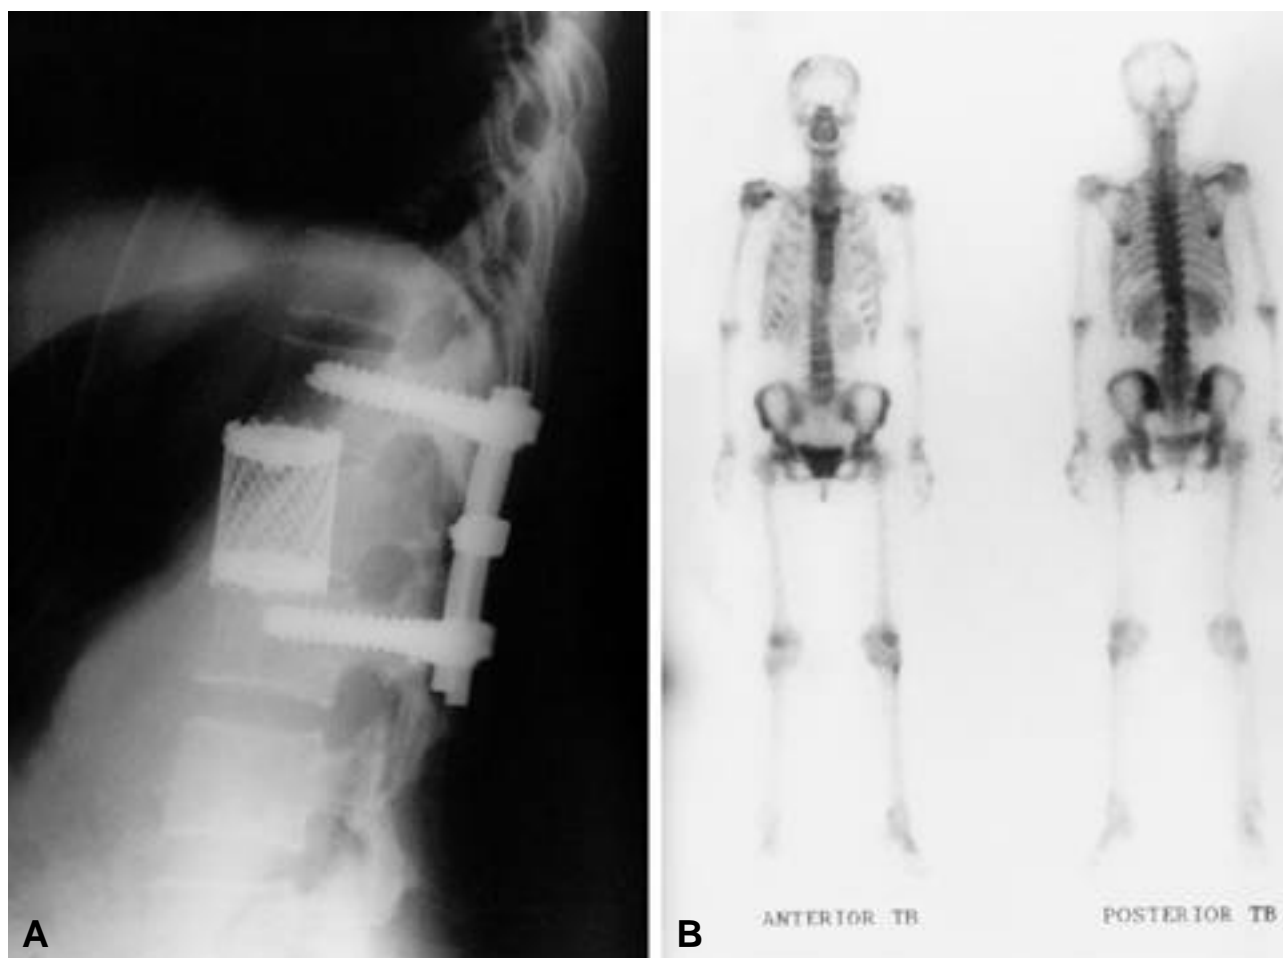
A,B Postoperative lumbar lateral radiograph and bone scan show no evidence of recurrence.
